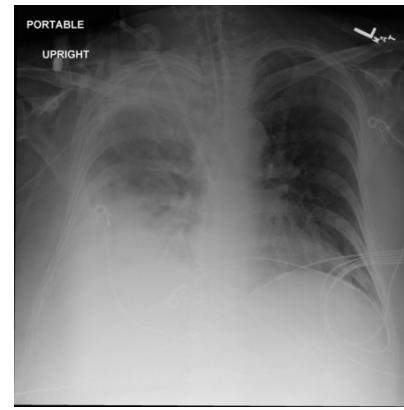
Chest radiograph demonstrated a right pleural effusion.
